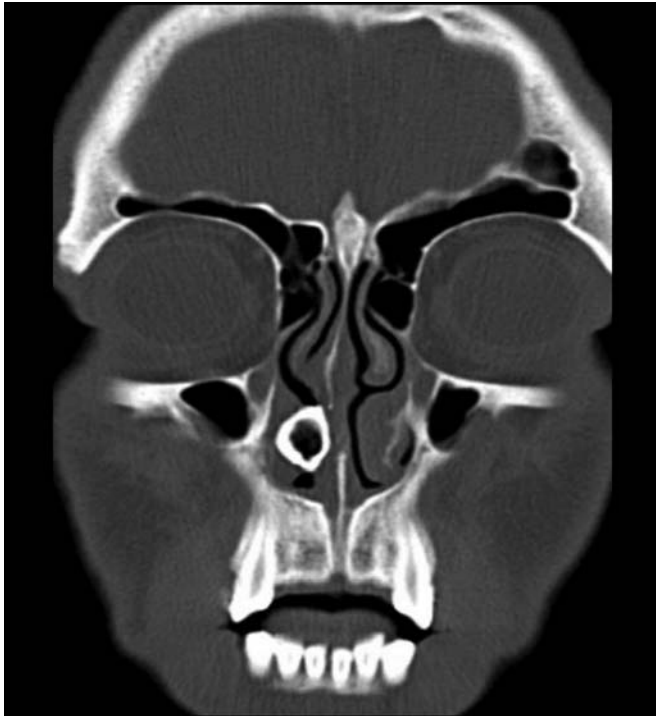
Coronal CT showing rhinolith in the right nasal cavity.
